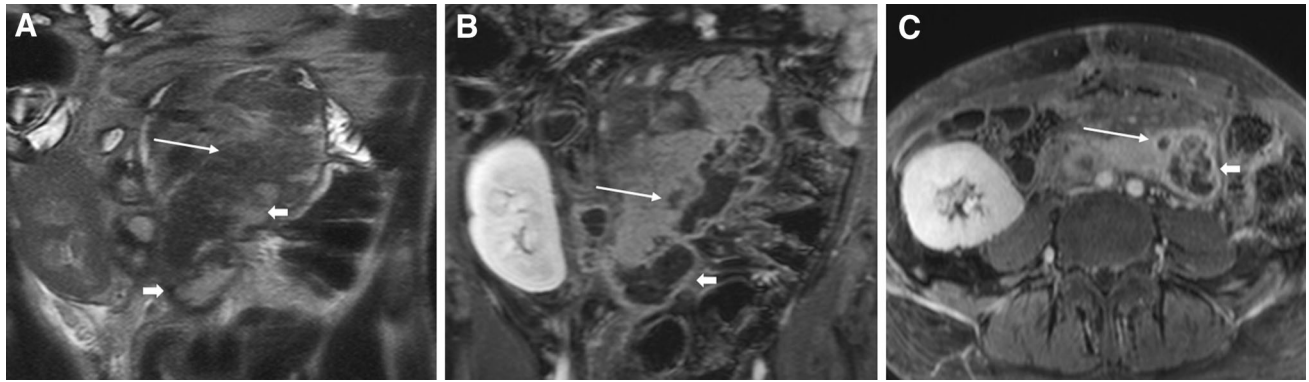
40-year-old man with abscess of transplanted pancreas and peripancreatic tissue. A Coronal T2-weighted image shows edema of pancreas (*long arrow*), heterogeneous hyperintensity of pancreas (*short arrow*). B, C Coronal (B) and transverse (C) T1-weighted image post-contrast enhancement shows rim enhancement of transplanted pancreatic parenchyma (*long arrow*) and peripancreatic tissue (*short arrow*).
